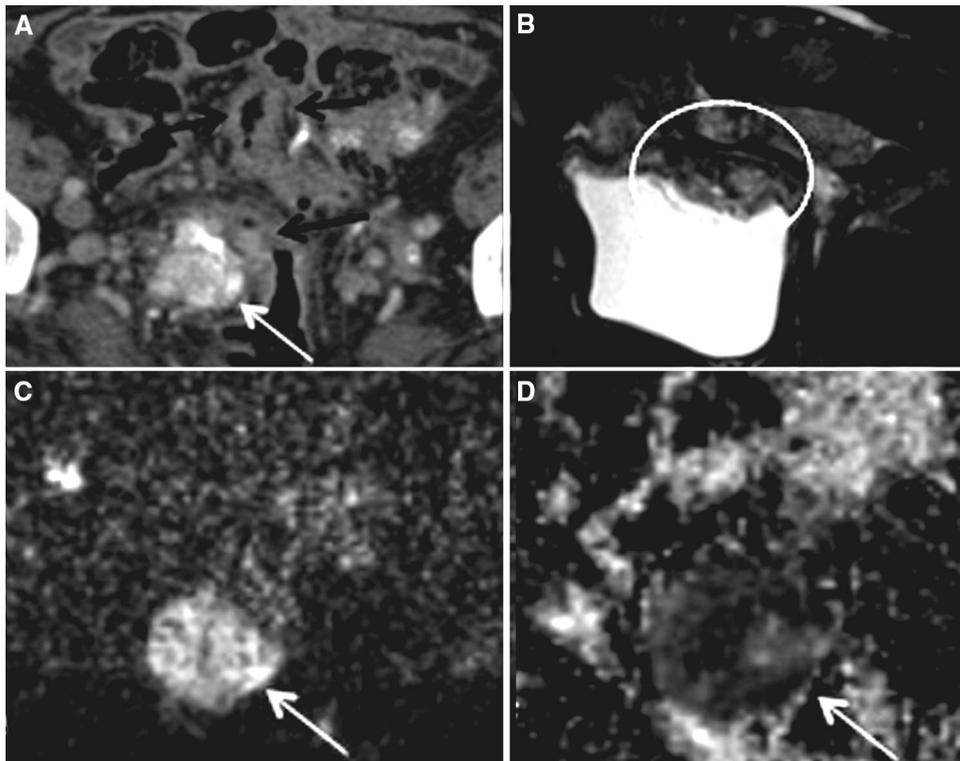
EOC recurrence within the pelvis. In 81 years old patient who underwent surgery for EOC, a 2 years follow-up CT scan showed local recurrence as a pelvic solid enhancing mass (A; white arrow) and diffuse sigmoid colon walls thickening (A;
